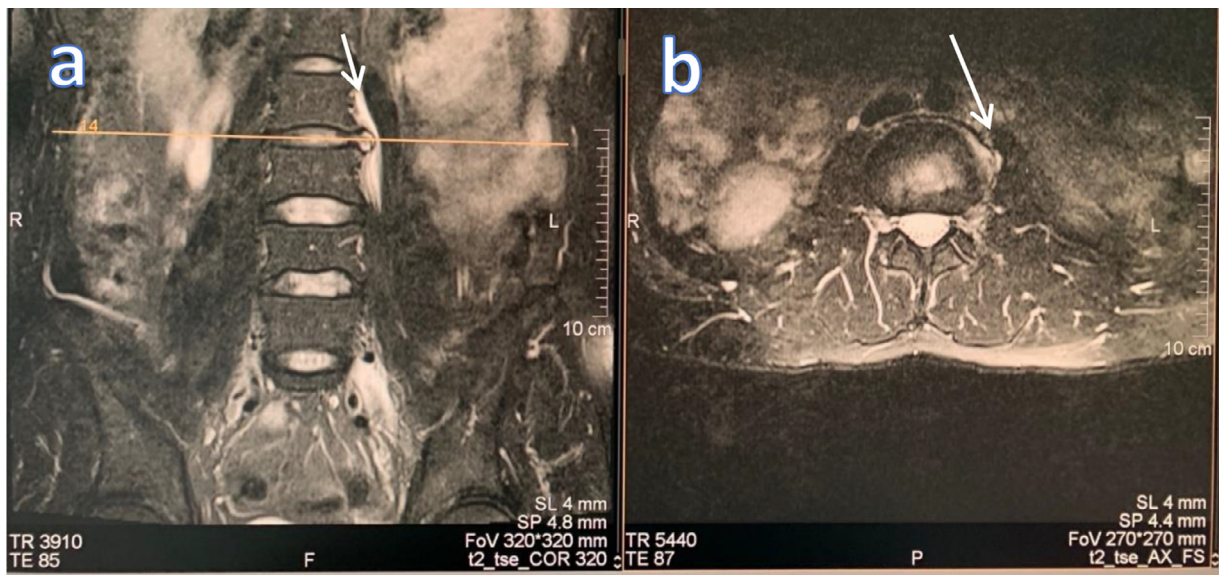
Standard (a) sagittal and (b) axial T2-weighted turbo spin echo sequence at the level L2-L3 of the lateral protrusion (shown by arrow)
